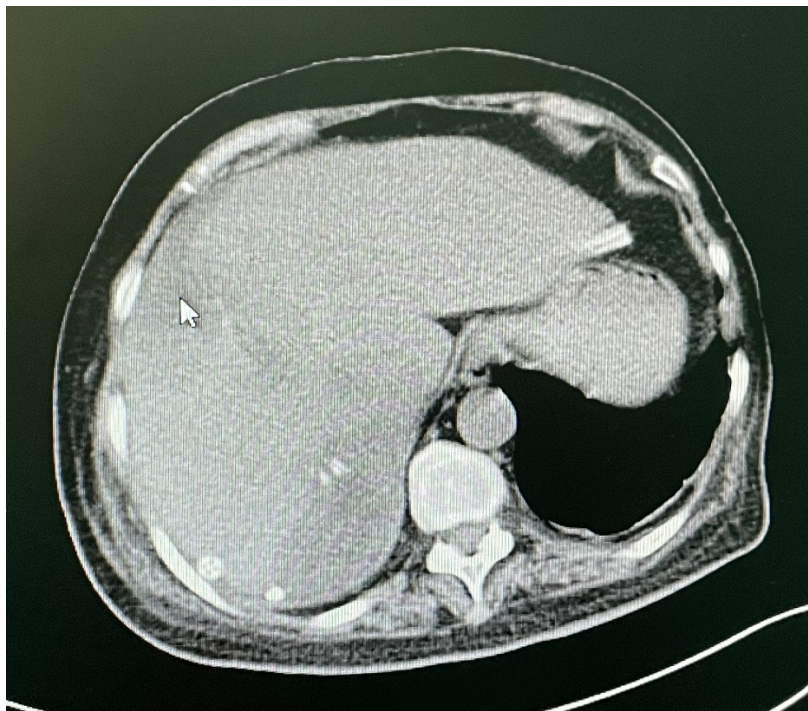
Abdominal computed tomography (CT) findings suggestive of liver metastases.
